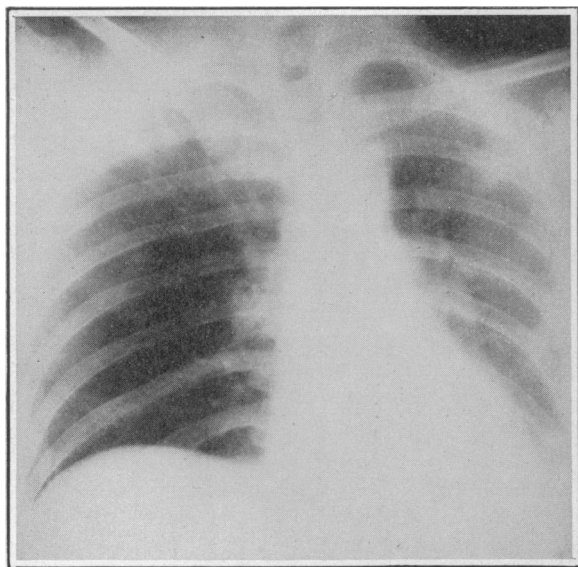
Roentgenogram demonstrating immediate improvement after turning patient on right side followed by prompt expectoration of a thick mass of sputum. Case 2.
